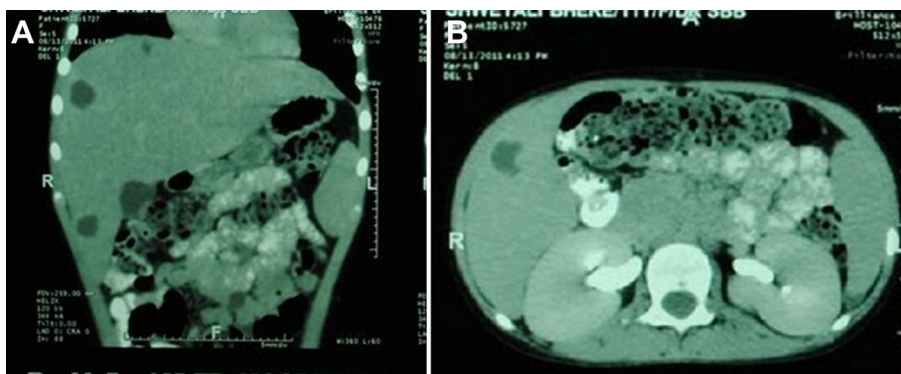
Computed tomography images. (A) Multiple nonenhancing subcentimetric and few enlarged hypodense lesions noted throughout the liver, largest 1.9 cm × 1.9 cm in segment eight of liver. (B) Spleen: 10.6 cm with a hypodense area of 1.6 cm × 1.2 cm at the lower pole.
